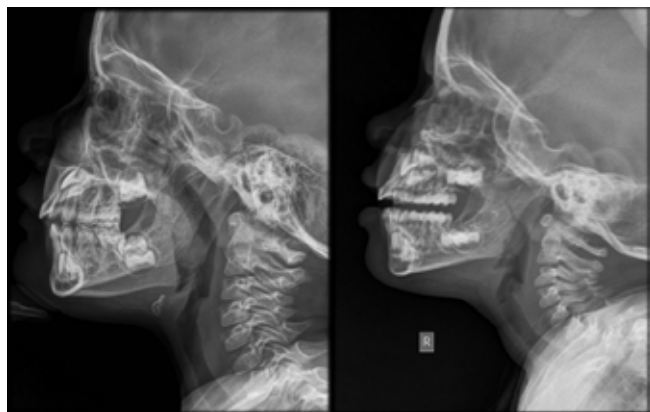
Comparative X-rays of the post-nasal space demonstrating obstruction of the nasopharyngeal airway due to adenoidal hypertrophy in the image on the right
